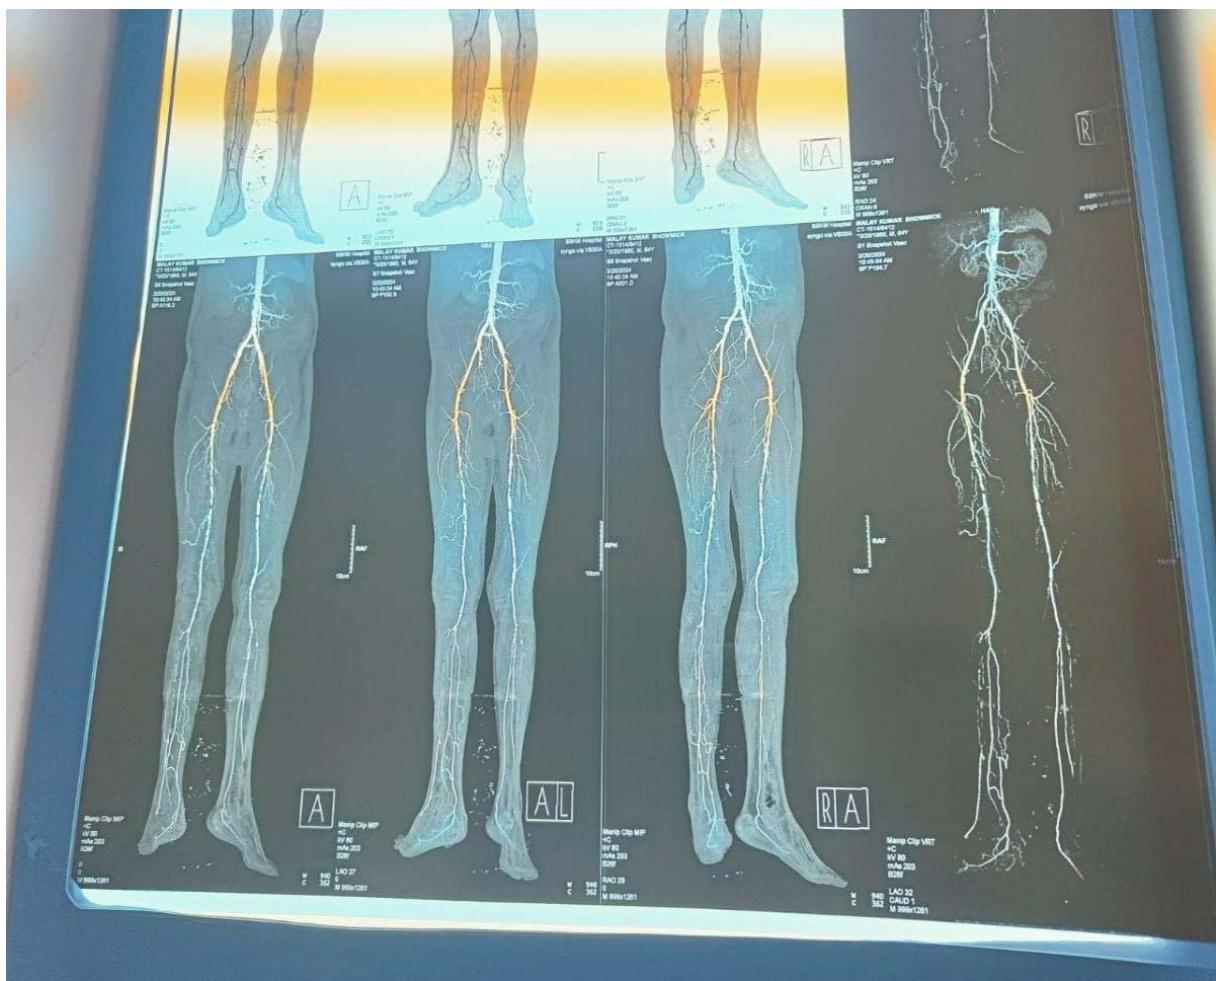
CT Angiogram of bilateral lower limb vessels showing peripheral arterial disease of a diabetic foot ulcer patient.
